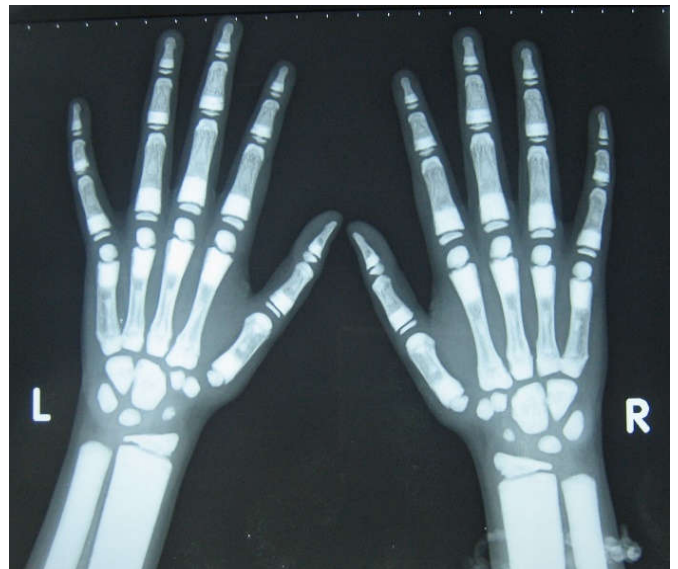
Hand wrist radiograph showed bullet shaped phalanges with dense metaphyseal bands
